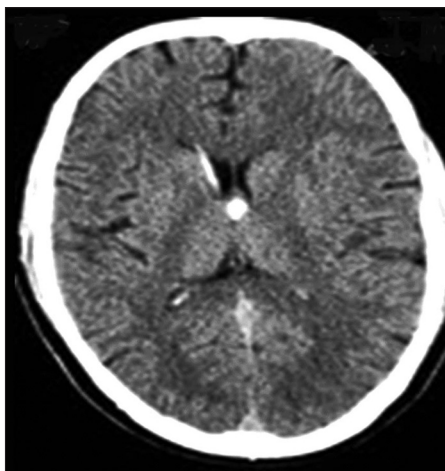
The patient was referred following a right VP shunt at a local hospital for hydrocephalus. The axial CT shows a hyperdense colloid cyst located posterior to the foramen. During surgery the foramen was narrow and the cyst could not be visualized. A subchoroidal approach through the velum interpositum helped in locating and resecting the tumor
